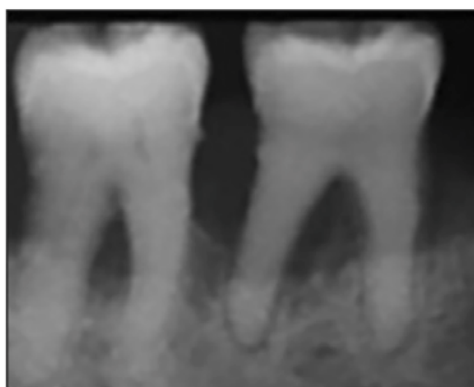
Periapical radiograph of pulp sclerosis with total obliteration of pulp structures #30.
